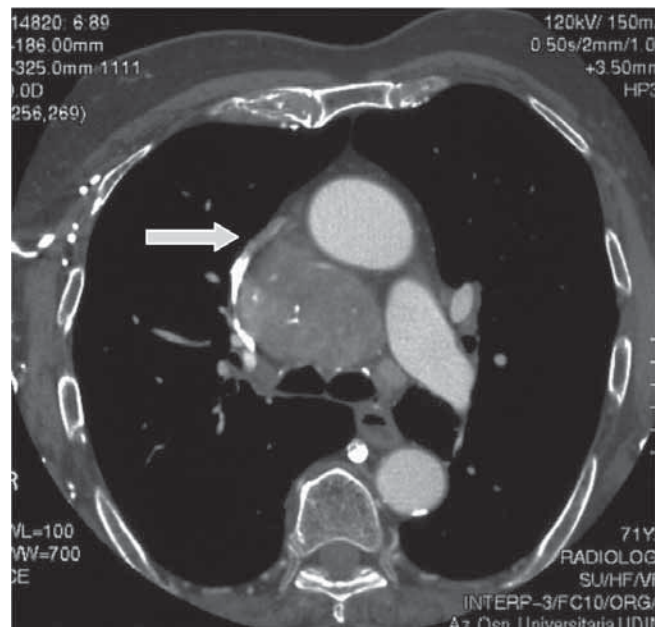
Axial CT scan showing extension of goitre below main bronchial bifurcation and significant vascular displacement and compression especially of the cava vein (white arrow).
